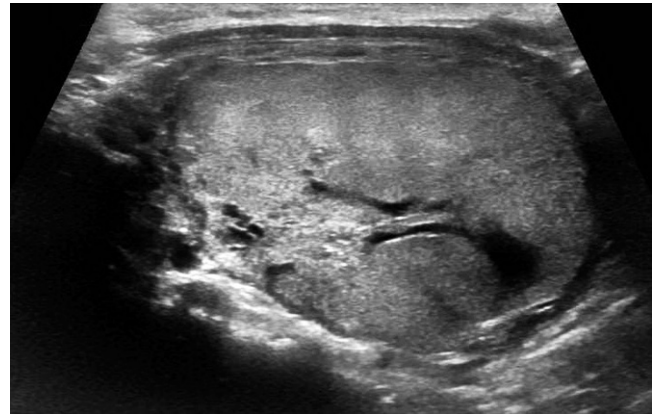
The longitudinal gray scale sonographic image of the right thyroid lobe shows a large, solid, isoechoic nodule with a thin hypoechoic rim that nearly replaces the lobe.
